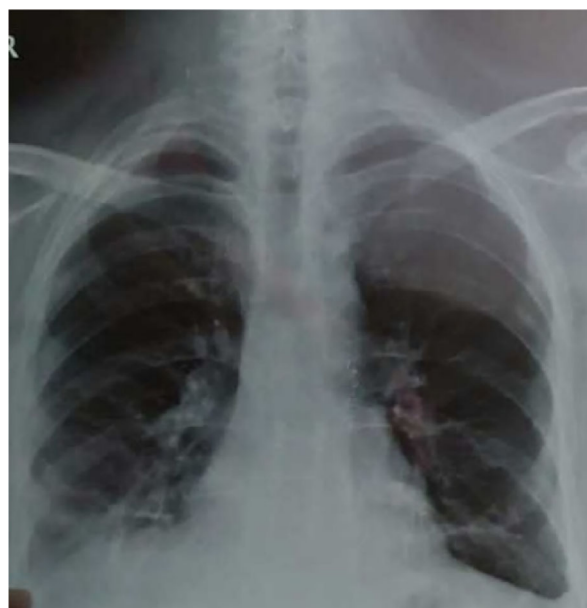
Post-transplant chest x-ray
